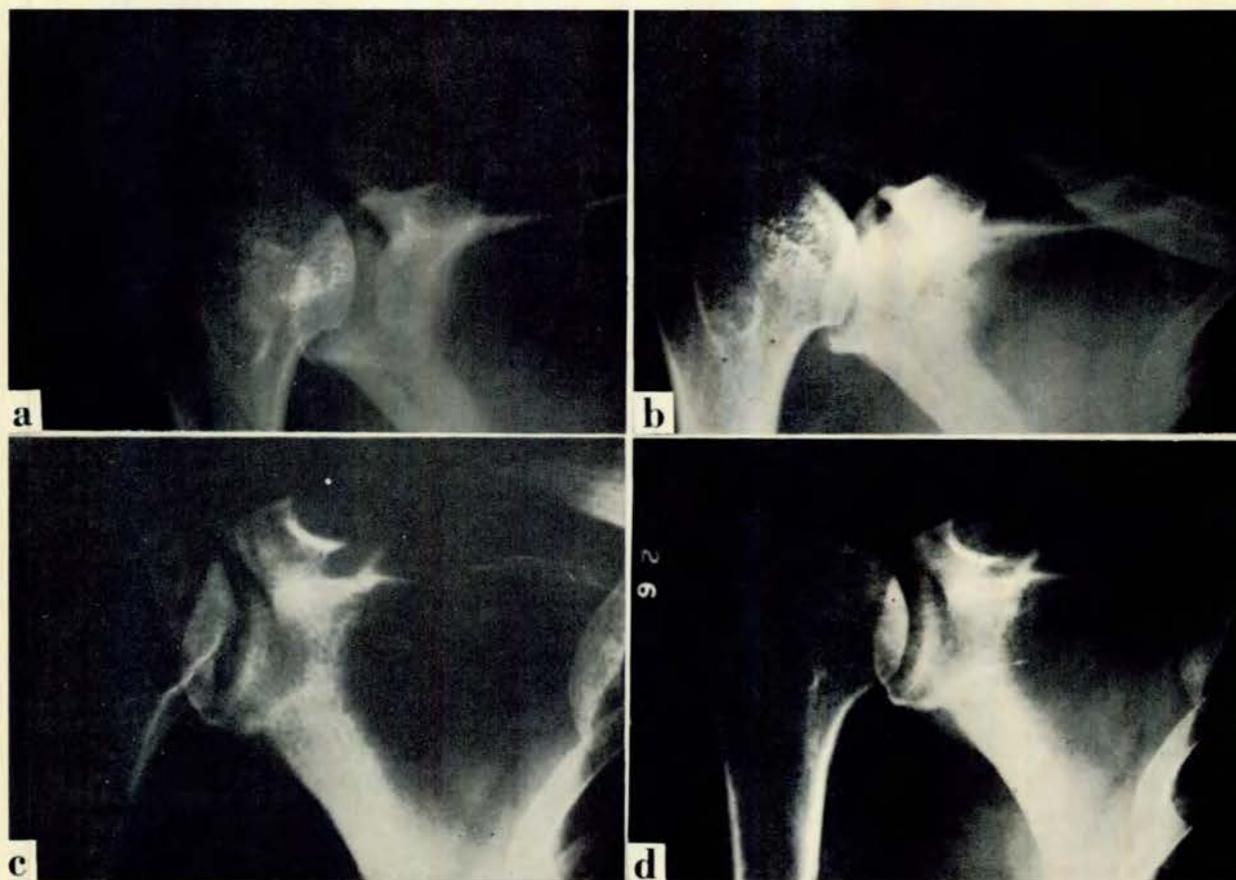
(a) Shoulder of man who had suffered an attack of bends; (b) same shoulder one year later, during which time patient had worked in pressures up to 30 psig; (c), (d) X-rays of same shoulder with different rotation.
